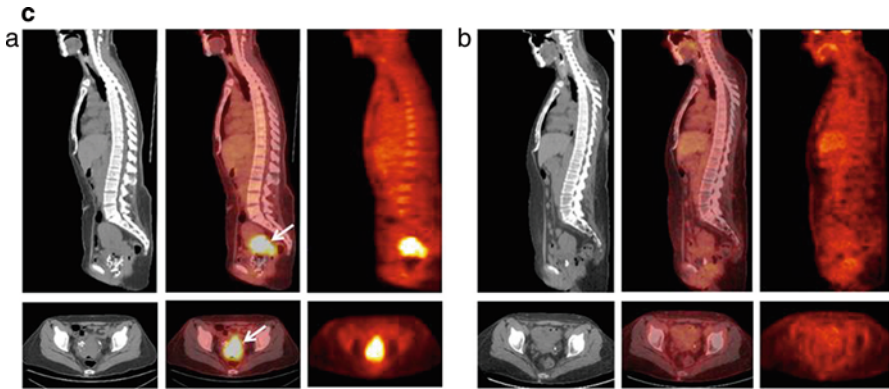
(continued) FDG-PET imaging depicted the most pronounced decrease in tumor volume post therapy compared to CT or MRI. Modified and adapted with permission from [12]. (b) FDG-PET-based imaging to determine response to chemotherapy. (a) High FDG-PET uptake of 2- ^{18}F fluoro-2-deoxy-D-glucose (FDG) in a patient with lymphoma arrowed before (a) and reduced uptake after (b) drug chemotherapy, seen in the tumor and brain. Modified and adapted with permission from [54]. (c) Application of ^{18}F -FDG-PET to assess complete metabolic response. PET/CT image of 52-year-old women diagnosed with stage IVA squamous cell cancer of the cervix. (a) Sagittal (*top*) and transaxial (*bottom*) CT (*left*), fused PET/CT (*middle*), and PET (*right*) images taken at the initial stage demonstrate high ^{18}F -FDG uptake within the cervical mass. (b) Sagittal (*top*) and transaxial (*bottom*) CT image (*left*), fused PET/CT (*middle*) image, and PET (*right*) image taken 3 months after concurrent radiotherapy clearly showing resolution of cervical mass with mild or diffuse uptake of ^{18}F -FDG within the cervix, depicting complete metabolic response. Adapted with permission from [55]
